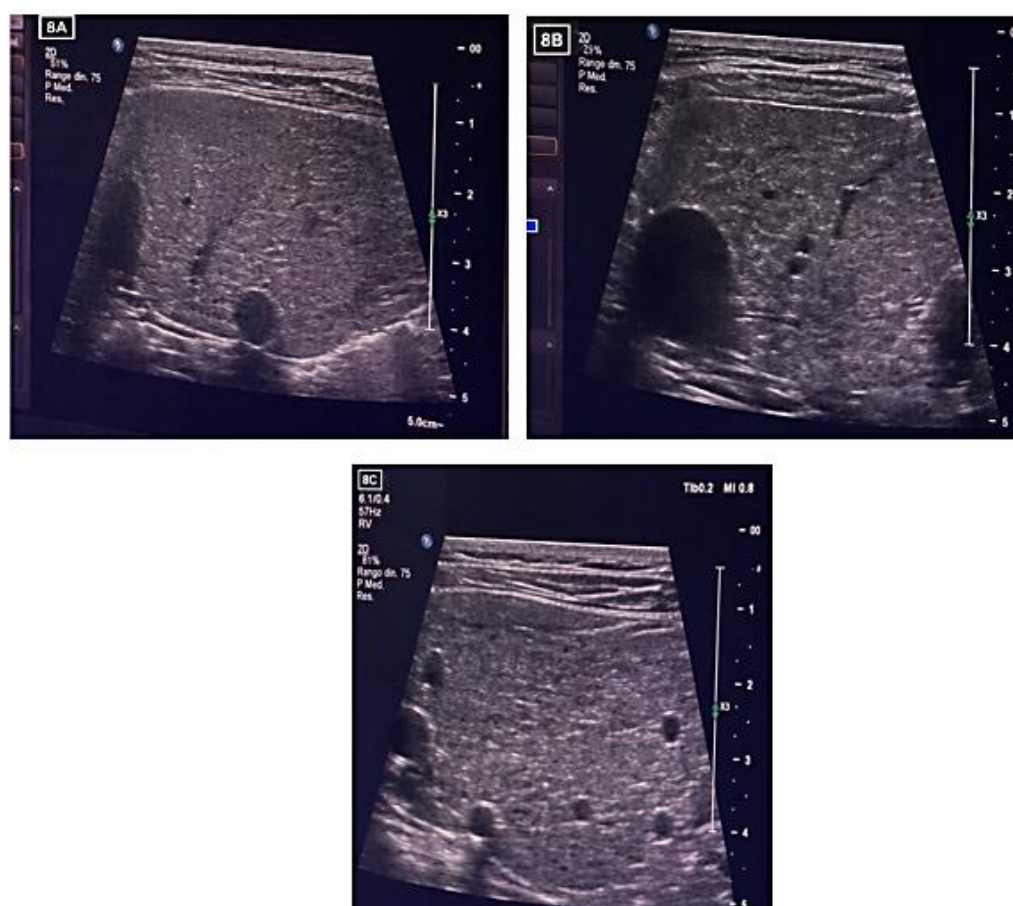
Neonatal abdominal ultrasound showing a prominent liver with a more central position than usual. The spleen was not identified in the left upper quadrant, findings suggestive of asplenia in the context of heterotaxy syndrome.
